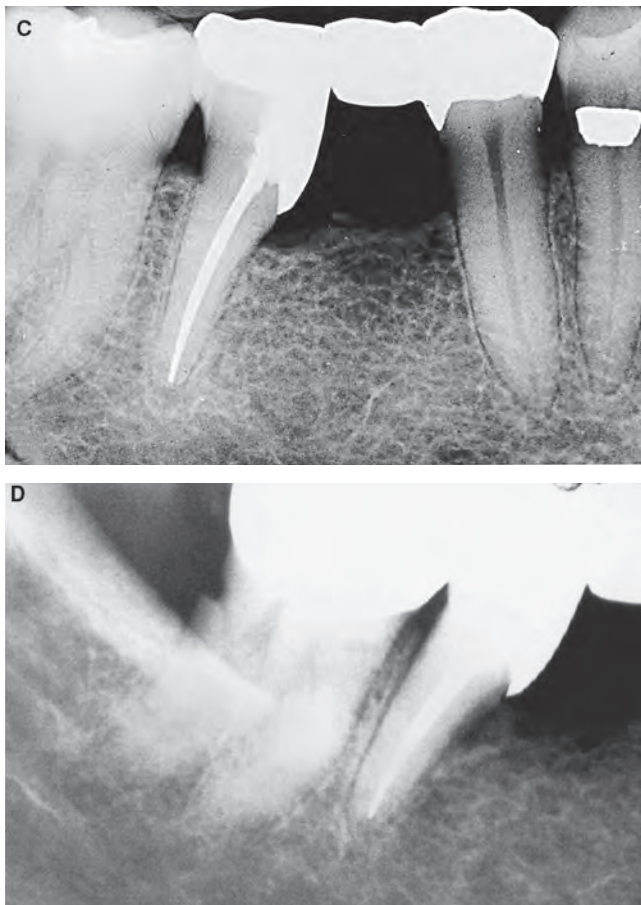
Continued. C, Final restoration of the space converts the first molar to a premolar. D, Radiograph taken at a follow-up 47 years later attests to the meticulous therapy and long-range efficacy of this procedure. Courtesy of D. Glick and J. McPherson.
